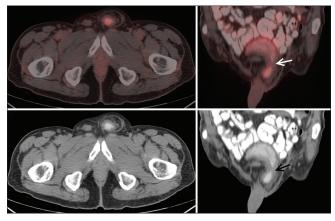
Delayed regional image of the pelvis showing clearance of tracer uptake and filling of contrast in the portion of herniated urinary bladder in the left inguinal canal, with a narrow neck (arrow) connecting it with the urinary bladder as shown in the delayed axial (a) and coronal (c) positron emission tomography/computed tomography and their corresponding computed tomography images (b and d, respectively)
